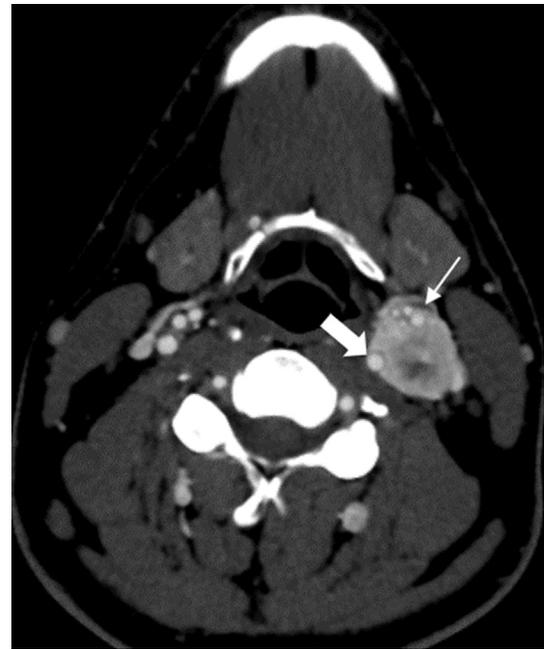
Axial arterial phase CT appearance of a left-sided carotid body paraganglioma. There is avid enhancement and splaying of the internal and external carotid arteries (thick and thin arrows respectively) indicating the paraganglioma is arising from the carotid body.
